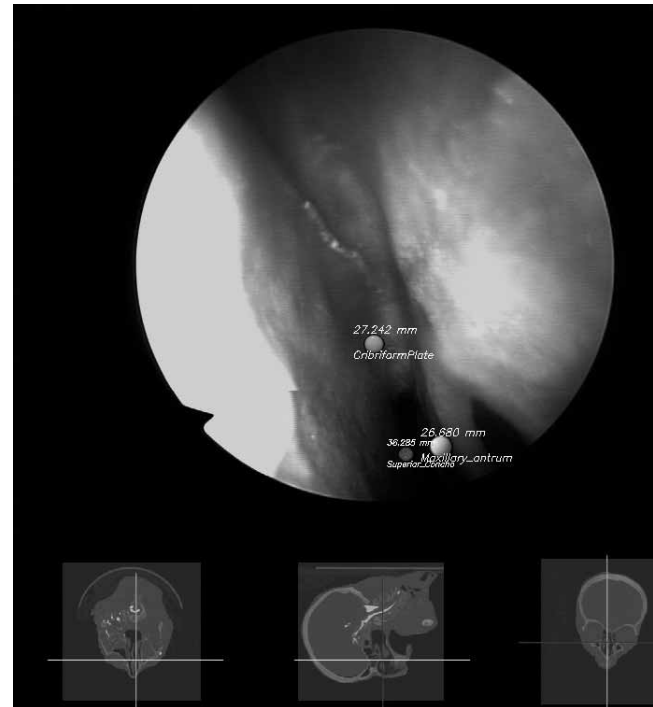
Distances from the endoscope tip to different anatomical landmarks with the corresponding endoscope position as crosshair on the CT are demonstrated.
